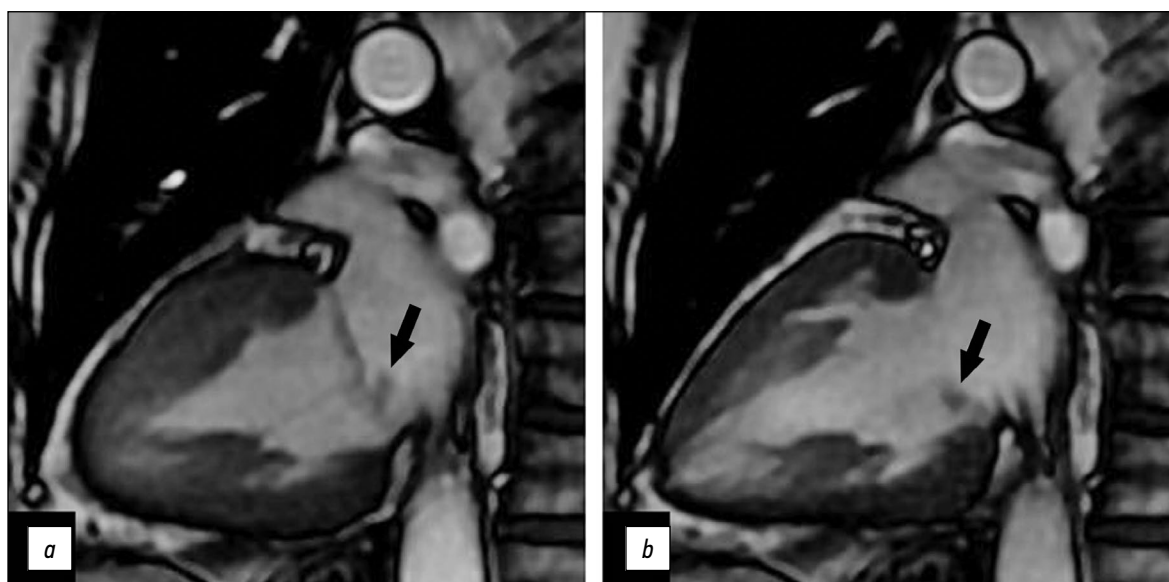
Magnetic resonance imaging of the heart, two-chamber view: *a*, left ventricular systolic phase; *b*, left ventricular diastolic phase. Additional mass on the posterior mitral valve leaflet (black arrows).
